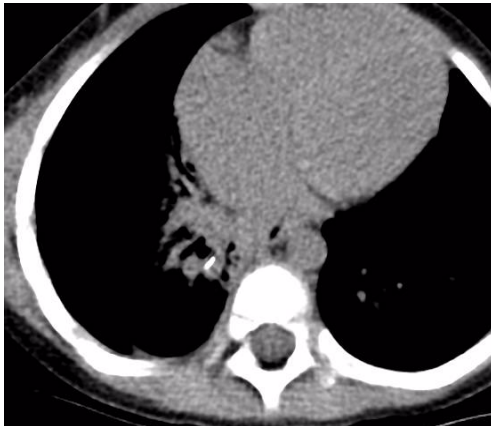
MDCT (axial views) showing right segmental bronchiole foreign body. MDCT, multidetector computed tomography.
